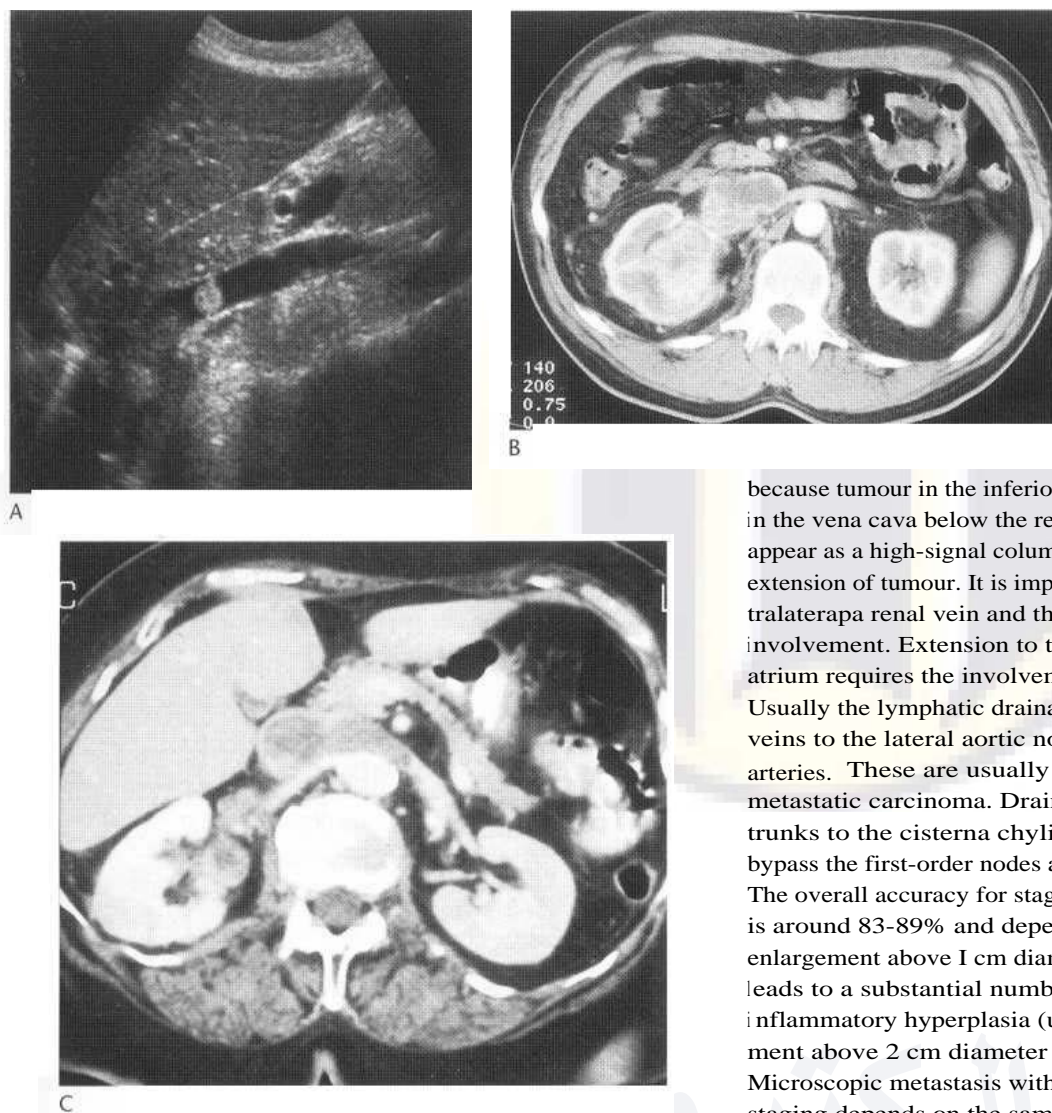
Renal cell carcinoma with vascular involvement. (A) Ultrasound shows tumour as a soft-tissue nodule of intermediate echogenicity within the inferior vena cava. Postcontrast CT (B, different case) shows a right renal cell carcinoma extending along the renal vein into the inferior vena cava and (C) into the contralateral renal vein.
